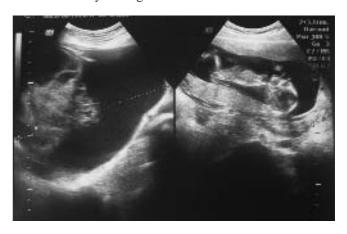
Ultrasonographic appearance of ovarian mass and pregnancy
